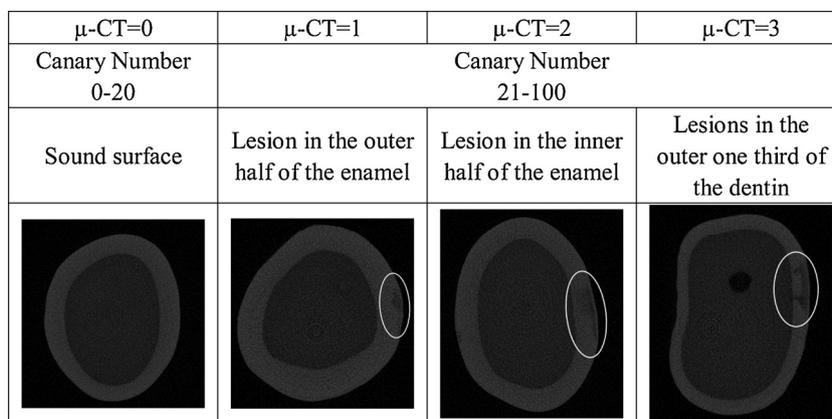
This figure represents typical cross-sectional images of  $\mu$ -CT image for each category. White circle indicates location of caries lesion.
